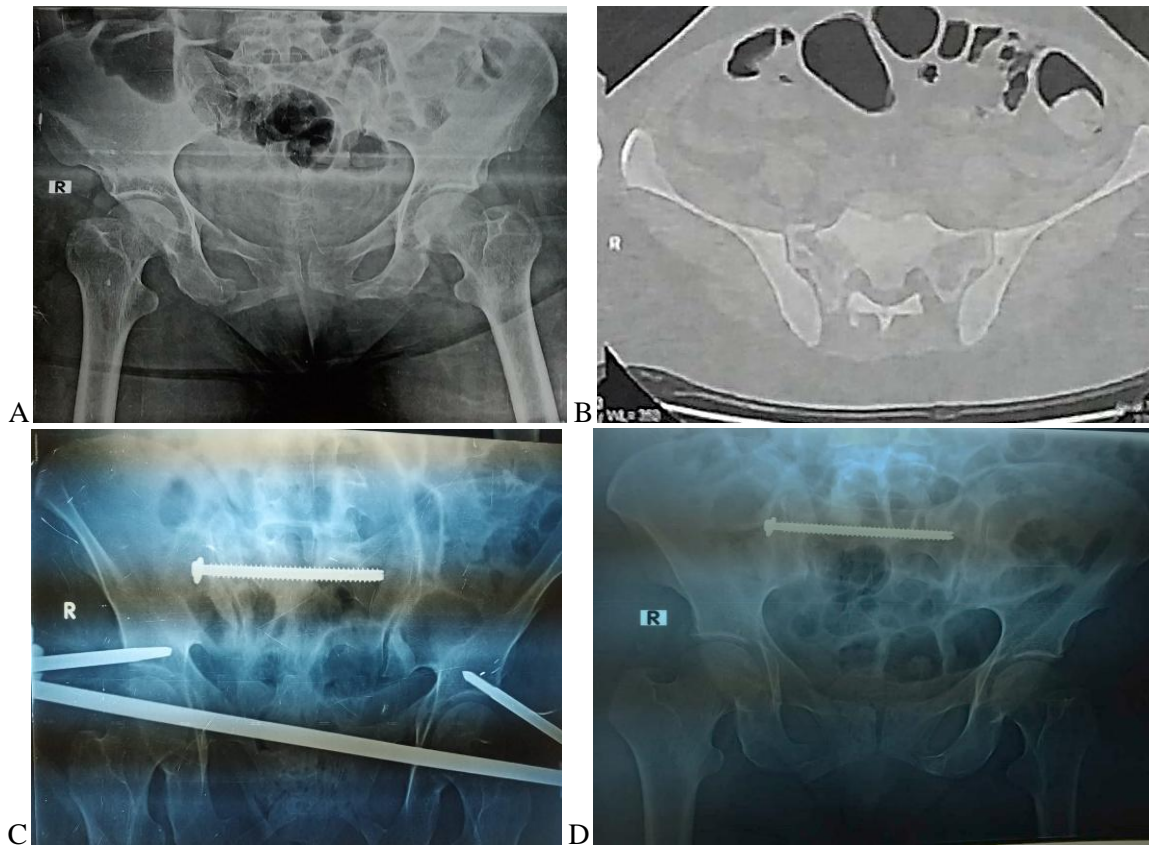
A: The plain AP view of 39-year-old male patient after falling from 1st floor shows type C injury of the *right* hemipelvis with ipsilateral superior and inferior rami fracture anteriorly and sacral fracture posteriorly B: The axial CT cut shows zone II *right* sacral fracture. C: The postoperative plain AP view after primary supraacetabular internal fixator application and washed percutaneous iliosacral screws application. D: The plain AP view after 6 months with good radiological score and excellent functional score.
